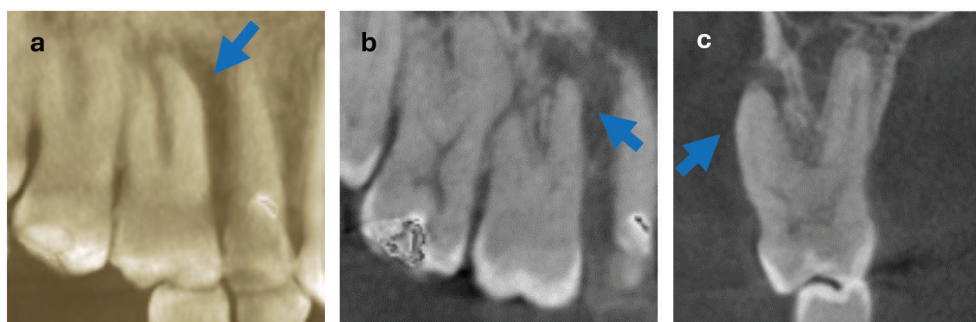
CBCT images showing vertical buccal bone loss extending to the apical region along the MB root (arrow) of tooth 16: 3-dimensional reconstruction views from (a) buccal; (b) sagittal; and (c) coronal.
